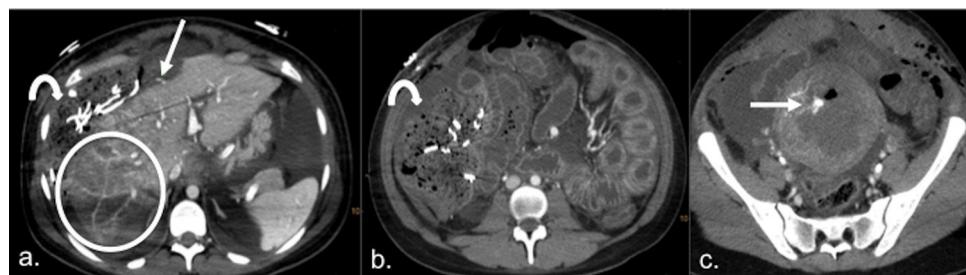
Hepatic rupture in a 26-year-old woman who had an emergency Caesarian birth due to pre-eclampsia and an emergency operation due to haemorrhagic shock. Postoperative computed tomography shows abundant haemoperitoneum and multiple hepatic (a, straight arrow) and uterine (c, straight arrow) foci of active bleeding. It also shows perihepatic haemostasis matter (b, c, curved arrows), hypodensity of the parenchyma consistent with ischaemia (a, circle) and significant oedema of intestinal loops (b).
